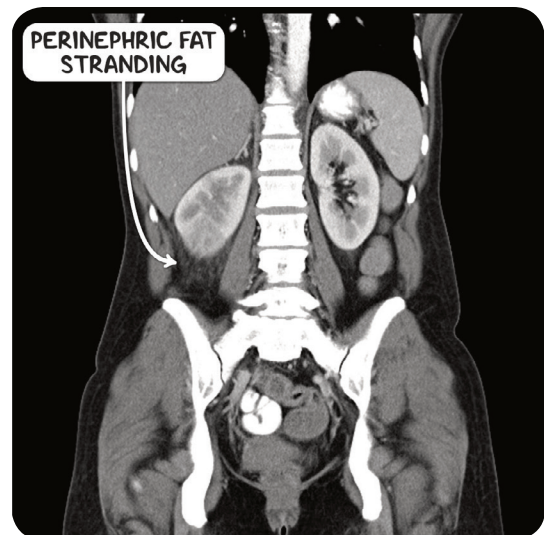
A CT scan in the coronal plane demonstrating perinephric fat stranding and cortical rim loss seen in acute pyelonephritis.
